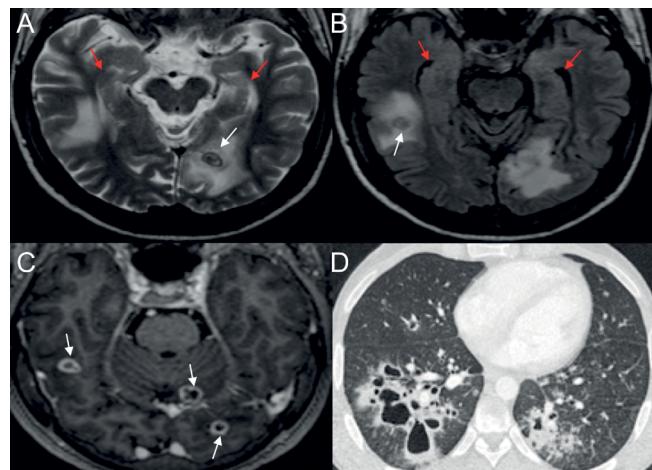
(A) and (B) — T2WI and FLAIR show lesions with low T2WI signal (white arrows) with vasogenic edema. Note the normal hippocampi (red arrows). (C) — T1 post-contrast shows lesions with annular enhancement (white arrows). (D) — chest CT with cavitated lesions.
